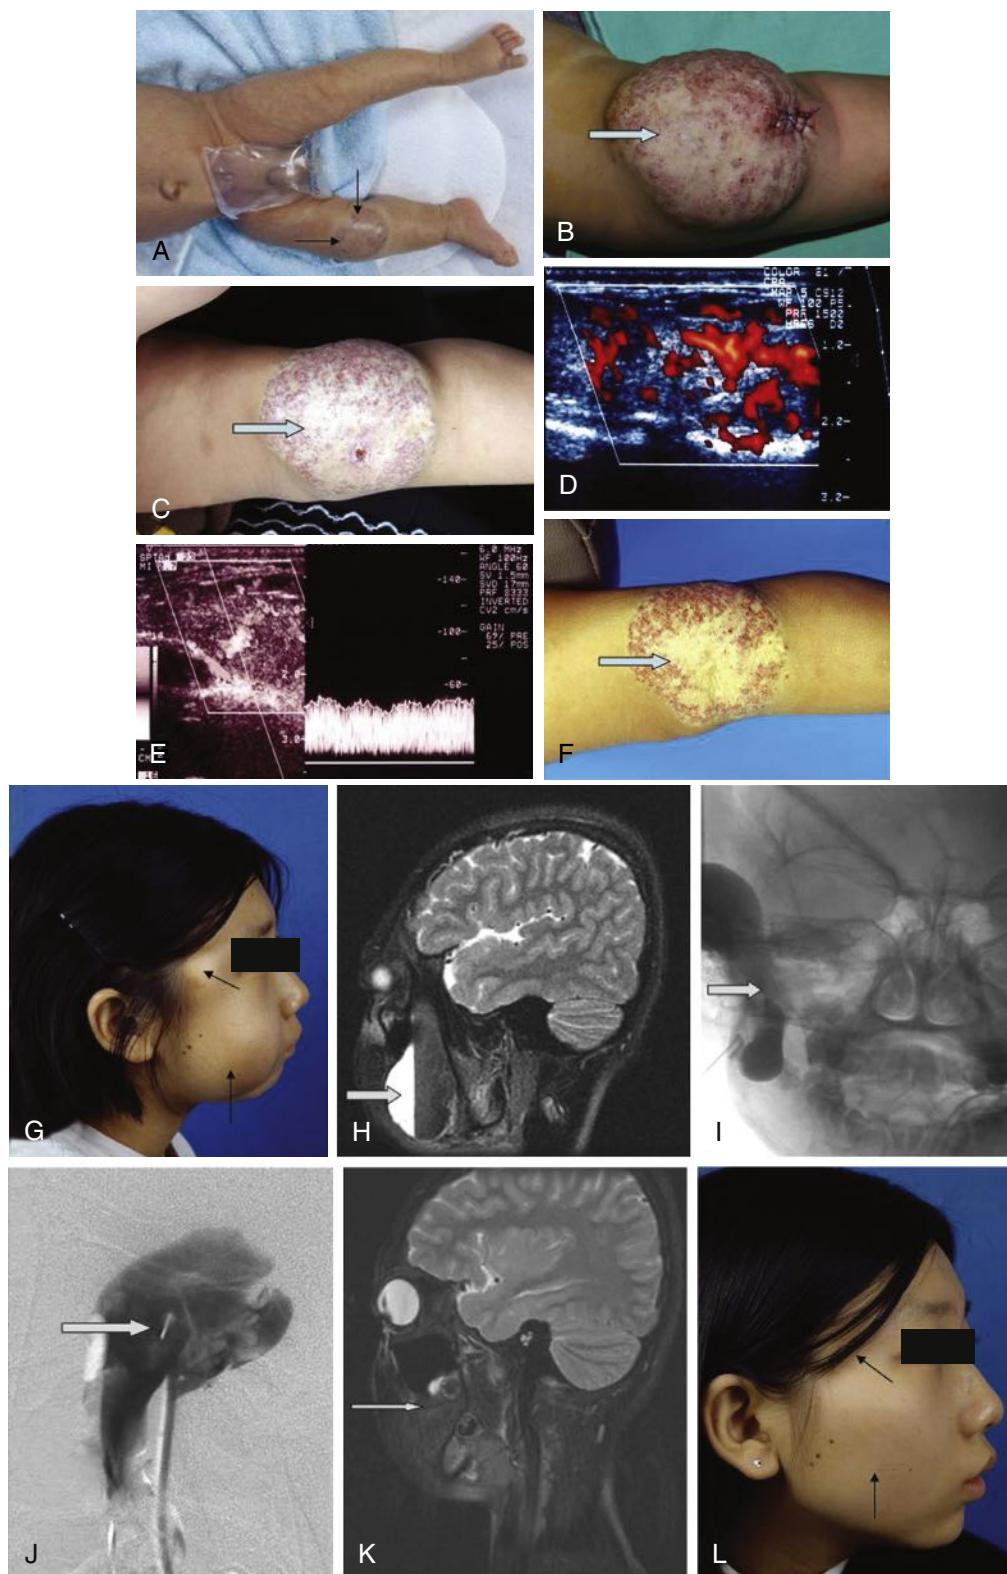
Hemangioma and Venous Malformation. (A–F) Hemangioma. In this infant, a hemangioma appeared 1 month after birth in a normal-looking area of the right lower thigh (arrows in A). The swelling grew quickly, reaching its peak size within a year (arrow in B). This was followed by a significant reduction in size during the second year (arrow in C). Duplex ultrasonography during the proliferative stage shows typical vascular hyperactivity along the tumor, with distinctly large feeding arteries (D and E). The lesion regressed almost completely, leaving only an area of skin discoloration, before the child reached 4 years of age (arrow in F). (G–L) Venous malformation (VM). This young girl was born with a swollen right cheek (arrows in G) – the site of a VM. The swelling was noticed at birth, but there was minimal change until menarche. Sagittal T2-weighted MRI depicts a large VM affecting the entire right cheek (arrow in H). Percutaneous direct-puncture angiography demonstrates a large cystic lesion (arrow in I). Percutaneous ethanol sclerotherapy resulted in complete control of the lesion (arrow in J), as shown by MRI (K) and a clinical photograph (L) taken at the 3-year follow-up visit.
